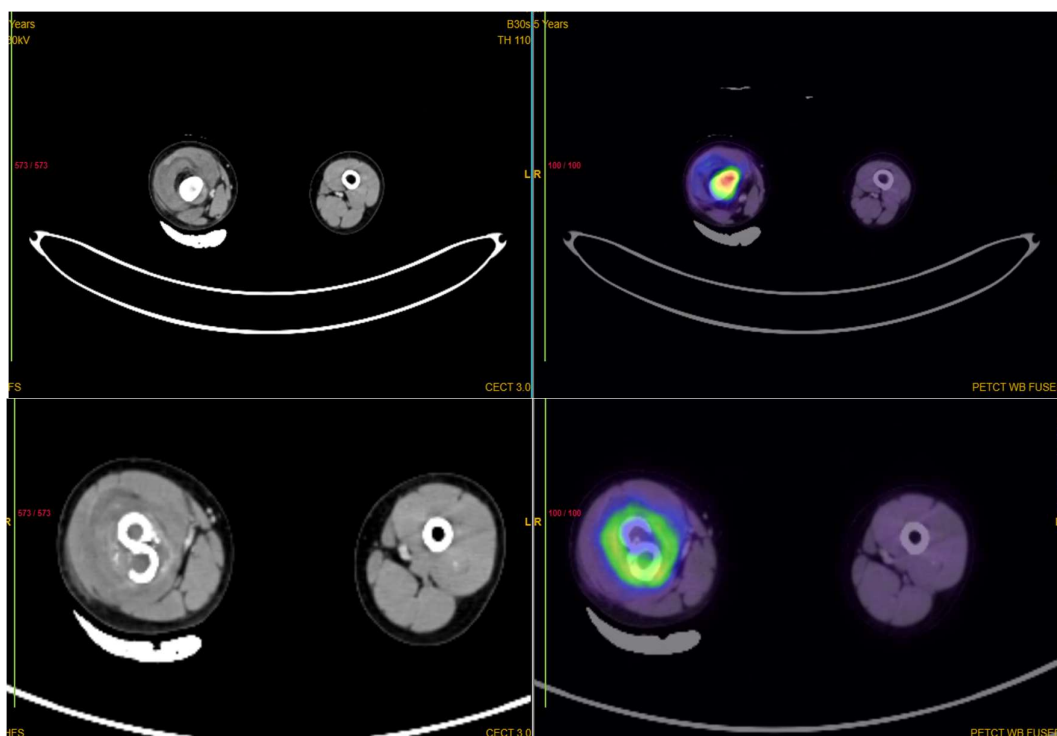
Case 1 – Post-traumatic FDG Uptake - Axial CT, PET, and fused PET/CT images of a 5-year-old male with a history of left adrenal neuroblastoma status post adrenalectomy, presenting after a recent fall. The images demonstrate focal increased FDG uptake in a long bone, raising suspicion for skeletal metastasis on PET-alone evaluation. However, corresponding CT images reveal cortical irregularity and features consistent with fracture, without aggressive bone destruction.
